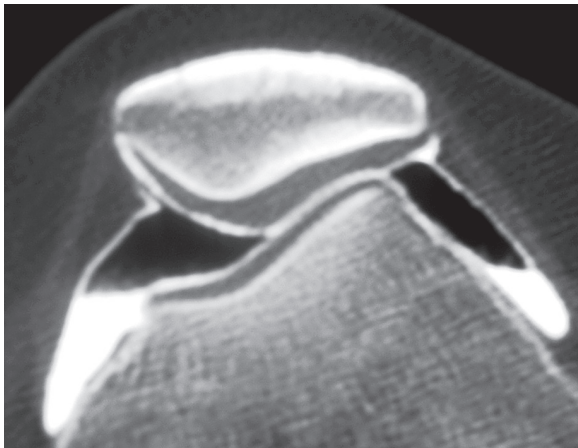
Increased sclerosis in the lateral patellar facet subchondral bone is indicative of a localized chronic increase in pressure. This double contrast CT arthrogram demonstrates intact articular cartilage on both the patella and the trochlea with an increased compression of cartilage at the lateral facet
